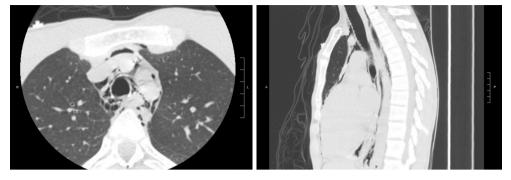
(X54999 CT airway protocol 02/15/2017). There is apparent discontinuity of both the anterior cartilaginous and posterior membranous trachea at the level of the arch vessels with associated extensive mediastinal emphysema. Direct visualization of the airway is recommended to exclude injury. CT, computed tomography.
